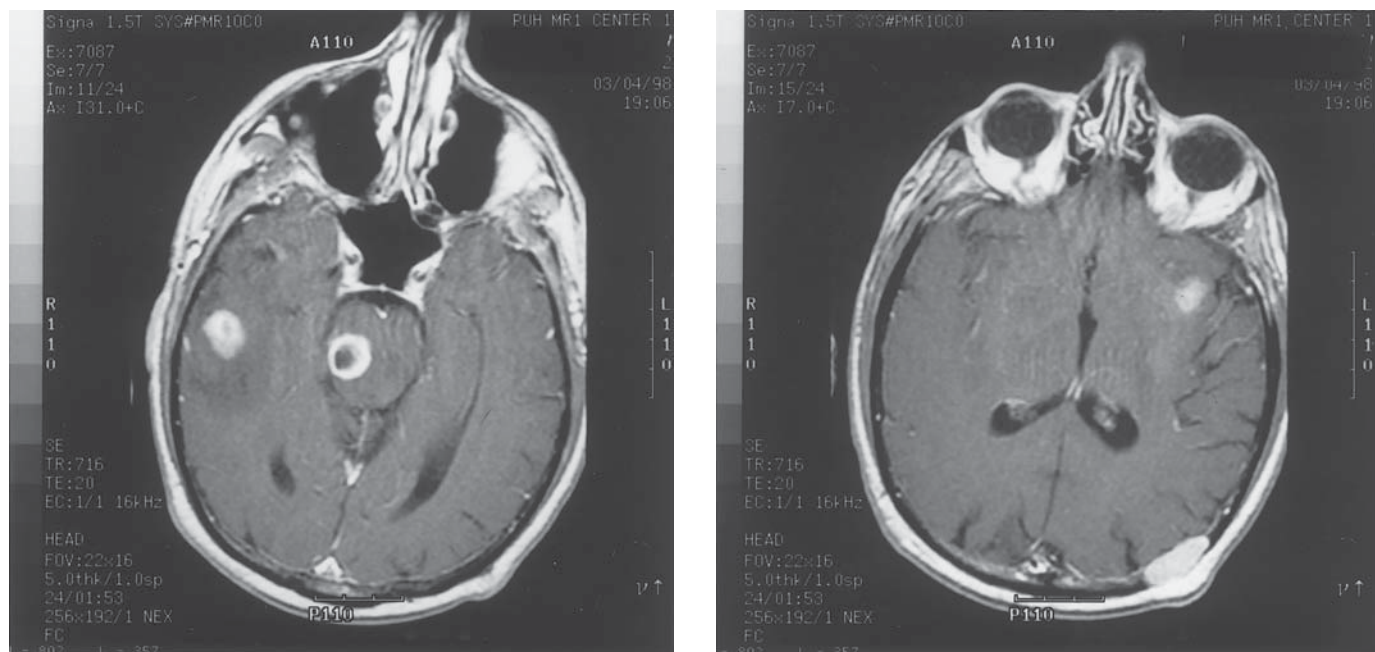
Multiple intracranial metastases from renal cell carcinoma. These gadolinium-enhanced MR images demonstrate three parenchymal and one calvarial metastasis. The left frontal parenchymal metastasis demonstrated precontrast T1 shortening and extracellular methemoglobin on other sequences indicative of hemorrhage.
